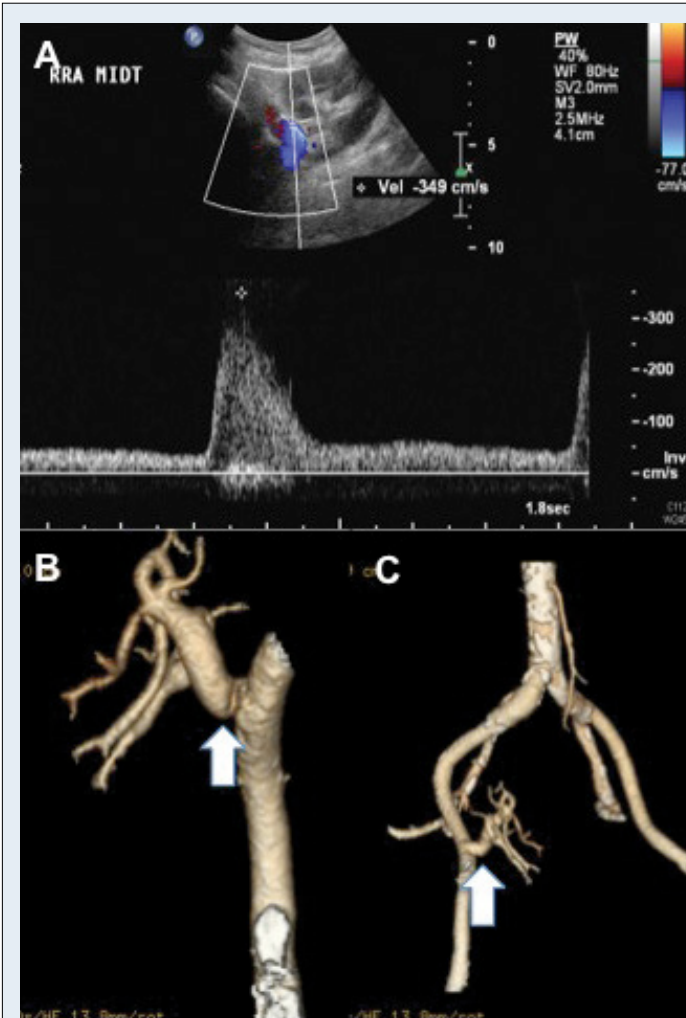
(A) Ultrasound examination at 15 months post transplantation showing a raised PSV of 349 cm/s at the origin of the renal artery. (B & C) CT angiography with 3-dimensional reconstruction showing a moderate kink at the origin/proximal renal transplant artery. Despite the other findings the intrarenal resistive indices were relatively normal (0.76 at the midpole, 0.7 at the lower pole and 0.8 at the upper pole) (B).
